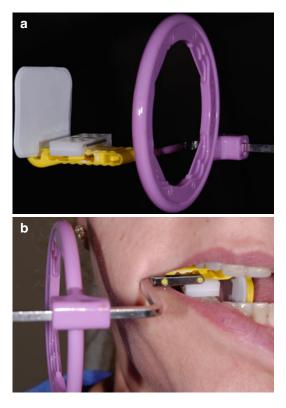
(a, b) How the PIXRL attaches to a paralleling device. Once the PIXRL is indexed to the implant, consistent standardized radiographs are possible to monitor bone health as well as confirm connection of the abutment
